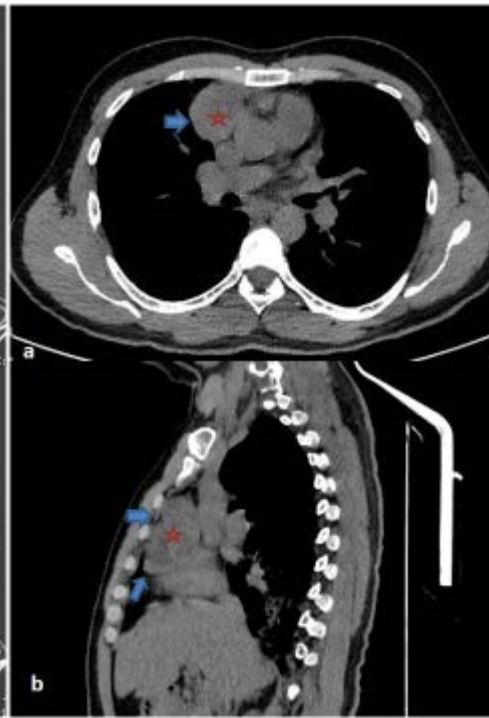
a) Axial ve b) sagittal CT images of the patient. The mass (star) adjacent to the vascular area.
